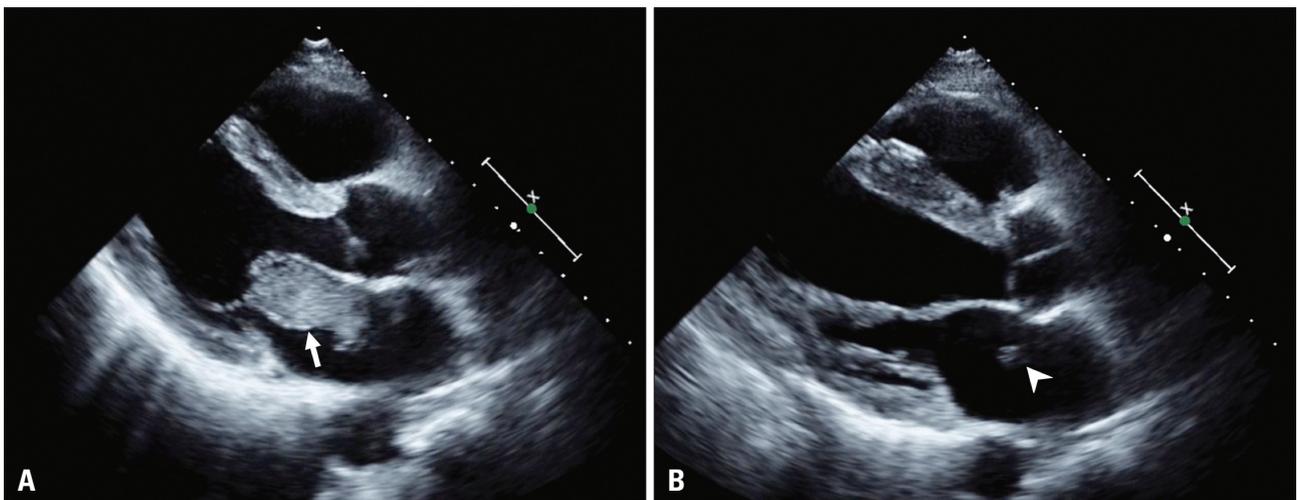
Echocardiography. A: Echocardiography showed a huge mass with heterogeneous echogenicity in the left atrium affecting through the mitral valve leaflet before six months ago, at the time of pembrolizumab treatment (white arrow). B: The left atrium tumor mass was significantly decreased at the time of admission in the echocardiography (white arrow head).
